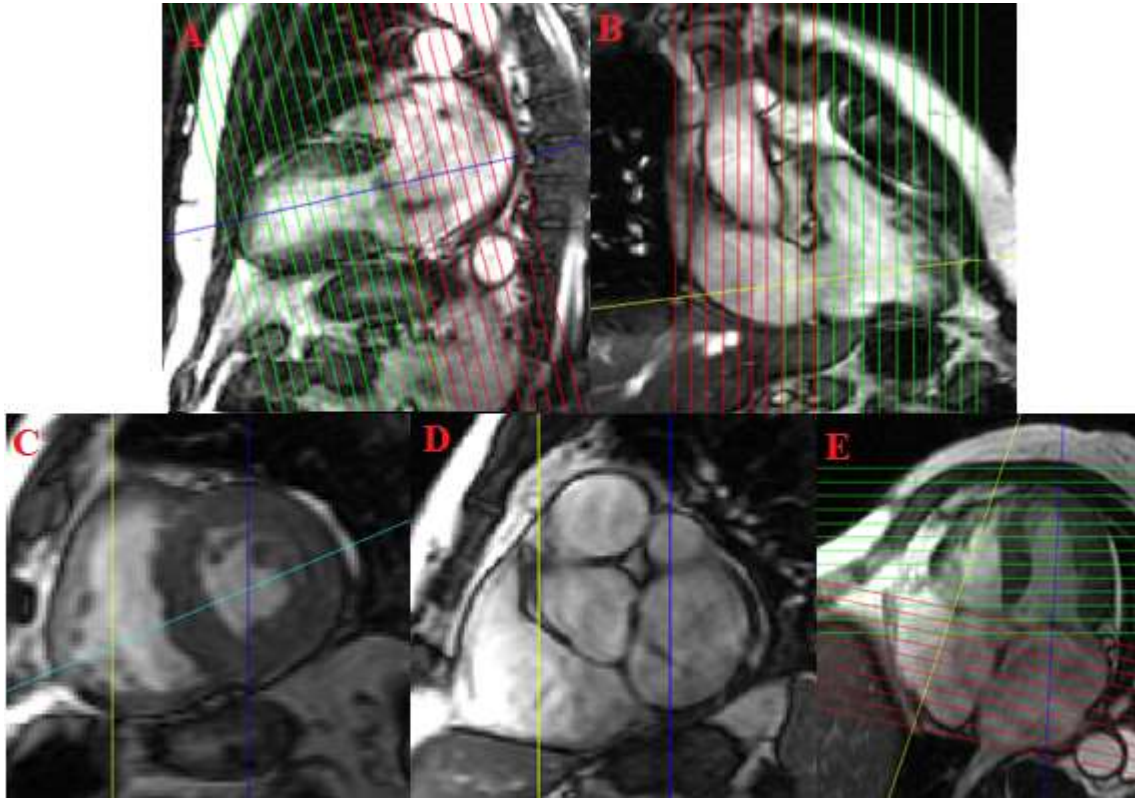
MRI imaging orientations and projections. A, C, E: standard two chamber, short axis and four chamber views respectively. B: extra right 2 chamber view. D: extra atrial short axis view. Projection lines, green- short axis view, red-atrial short axis view, yellow-right 2 chamber view, cyan-four chamber view, blue-left 2 chamber view.
